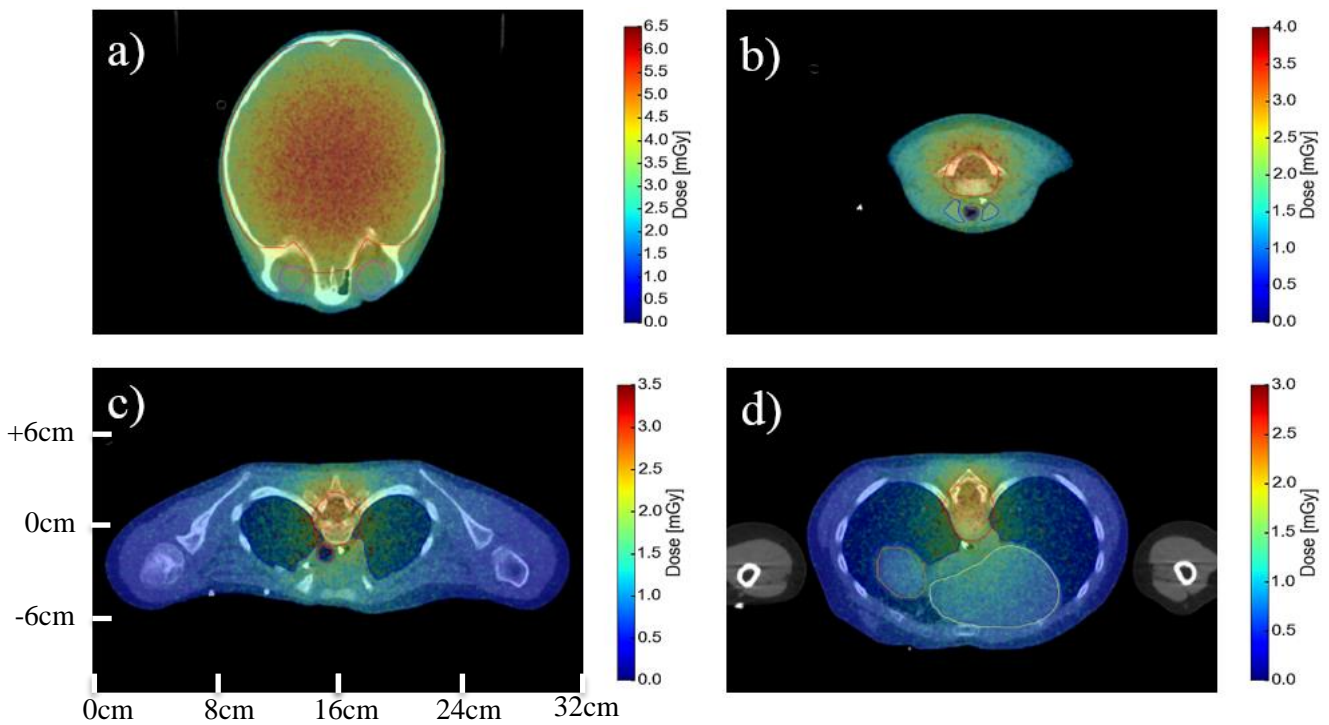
Visualization of the neutron absorbed dose distribution drawn upon the CT slices of the patient. The PTV is marked red. The eyes are seen in a), esophagus and trachea in b) – d), lungs, heart and liver in d). e) shows the location of the respective slices in the patient body.
